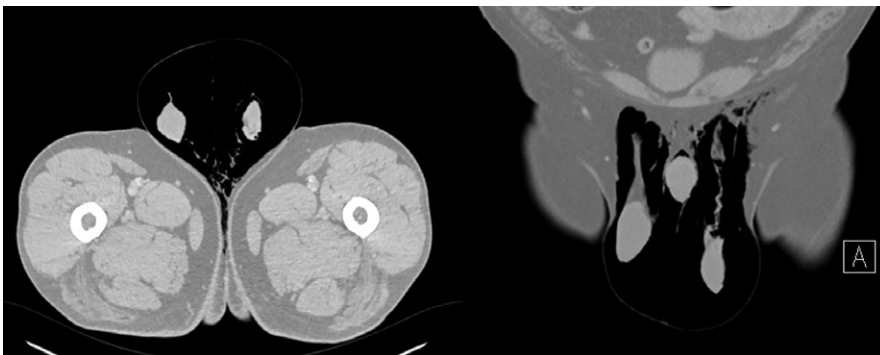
Postoperative CT scan—scrotum
